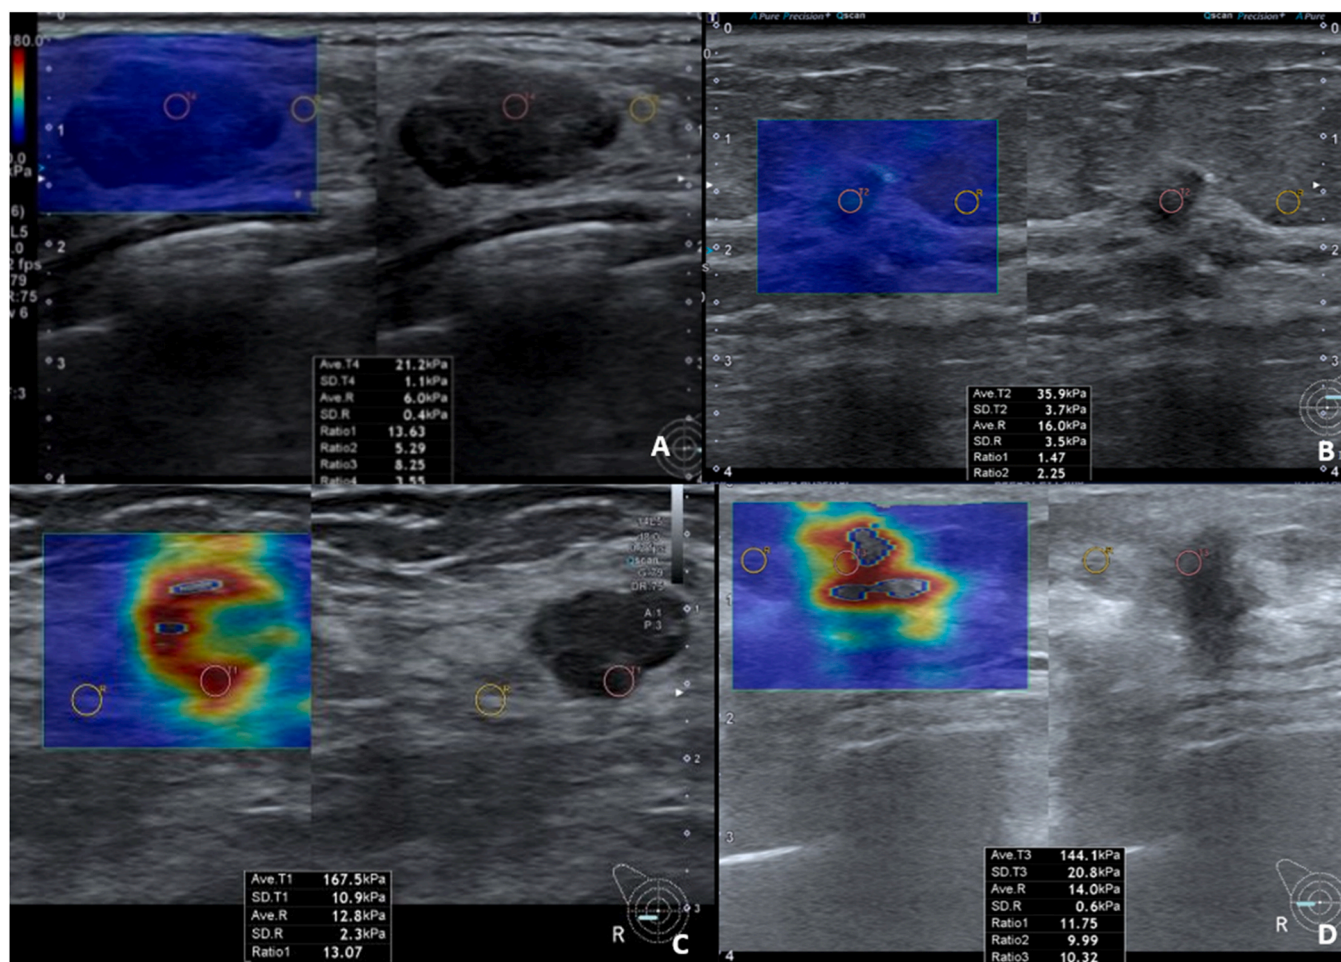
Fig. 1A. Shear wave elastography and grayscale ultrasound image of a 20 mm fibroadenoma. The shear wave image shows the lesion in homogeneous blue, defined the most stiffness site as inside tumor. The E-mean and E-ratio are 21.2 kPa and 3.55. Fig. 1B. A 7 mm invasive ductal carcinoma with homogeneous blue. The E-mean and E-ratio are 35.9 kPa and 2.25. Fig. 1C. A 22 mm invasive ductal carcinoma. The shear wave image shows the mass and surrounding tissue in heterogeneous color and the zone of stiffness is irregular in red, yellow, and green color. The most stiffness site is red and inside tumor. The E-mean and E-ratio are 167.5 kPa and 13.07. Fig. 1D. A 11 mm invasive ductal carcinoma defined the most stiffness site as peritumoral site. The E-mean and E-ratio are 144.1 kPa and 10.32.
